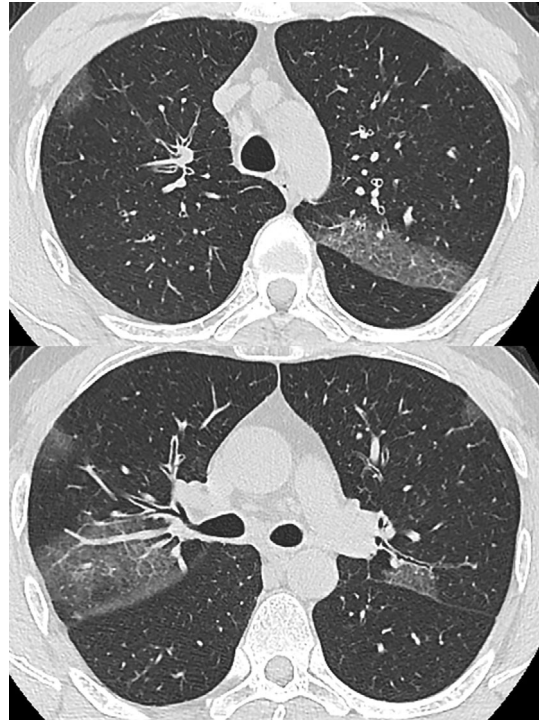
Chest CT findings in Case 4. Case 4 was positive for influenza virus A (H1N1pdm09 virus). High-resolution CT of the lung shows bilateral subpleural multiple ground-glass opacity with enlarged blood vessels. Airway-centric distribution of GGO and bronchial wall thickening are also observed.
